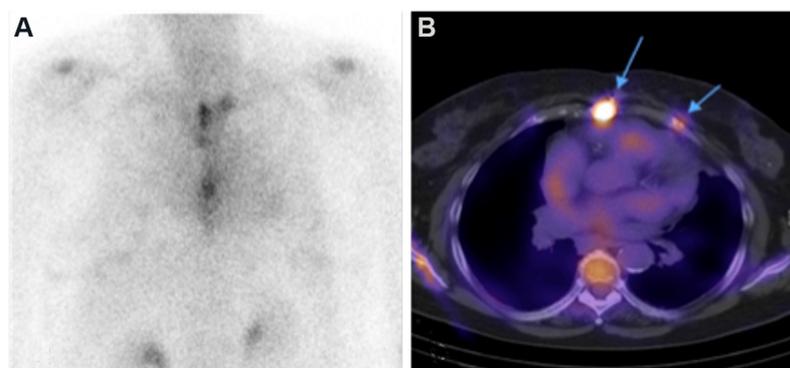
Technetium-99m pyrophosphate bone scan: (A) focal tracer uptake on planar images that overlaps the cardiac area; and (B) single photon emission computed tomography/computed tomography images show bone uptake.
